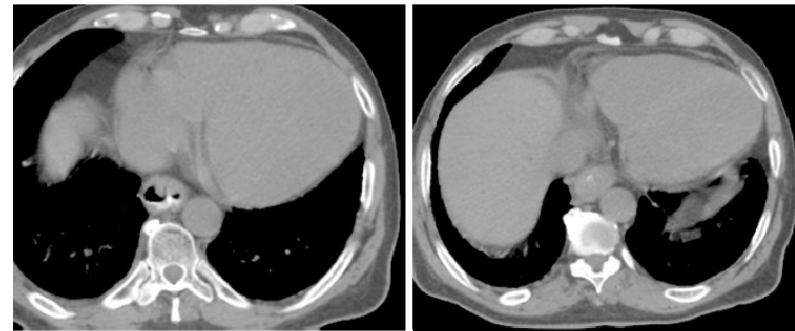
Non-contrast enhanced CT of esophageal cancer patient's chest. Image on left shows some oral contrast; image on right, which is caudad, demonstrates that the esophageal canal is almost completely occluded, with just a dot of contrast in the esophageal canal. Note fat plane between aorta and enlarged esophagus, which suggests this patient's tumor will be resectable with clean margins (R0). Images courtesy of the University of Massachusetts Medical School, Department of Radiation Oncology.
